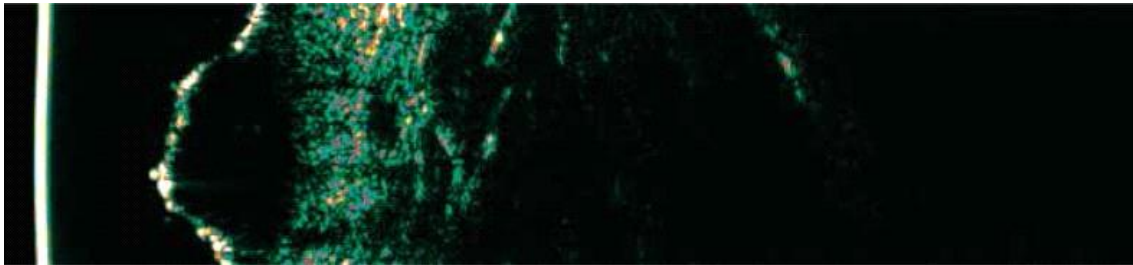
The figure shows the ultrasonographic image of BCC, location – neck [12].
